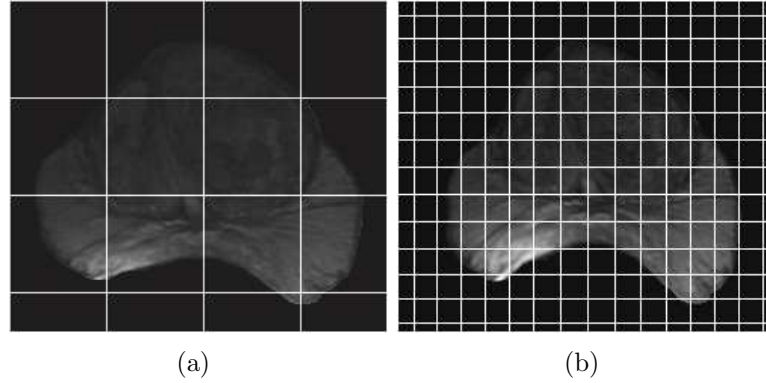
B-splines control grid with 2 refinements over the initial placement on the moving MR image of size  $219 \times 249$ . (a) shows the initial placement of the B-spline grids with  $64 \times 64$  pixel spacing on the moving MR image and (b) shows the final set of B-spline control grids on the transformed moving image.
